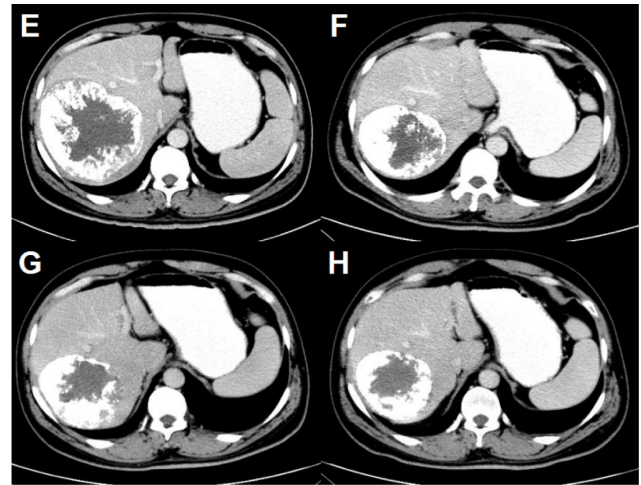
(E-H) After the second TACE, CT reexamination showed that the tumor gradually decreased, and AFP, the tumor marker of the patient, returned to normal.
